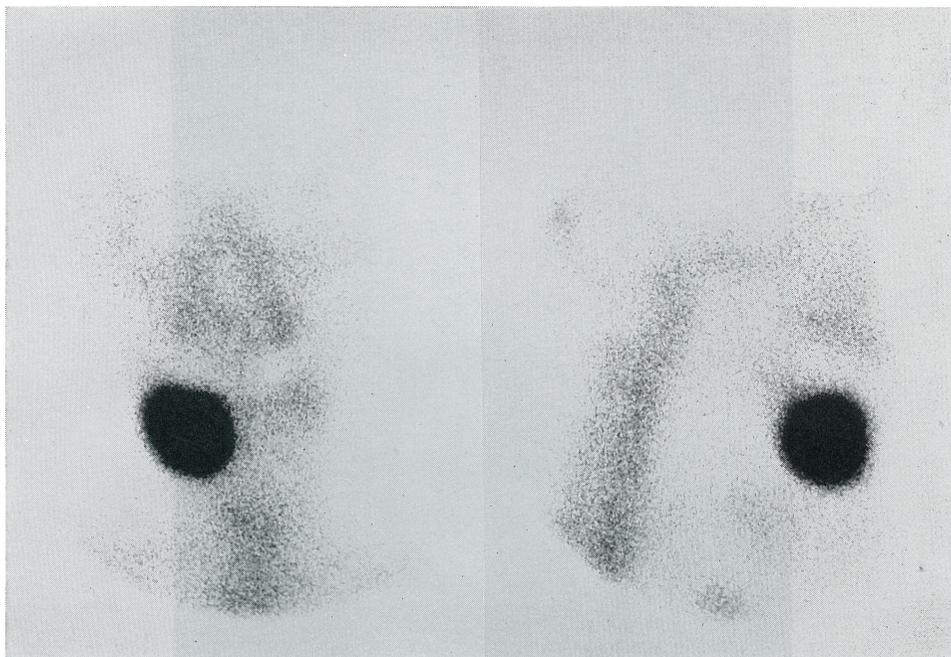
Bone scintigram (Anteroposterior and right lateral view). Diffuse increase in accumulation was seen over the whole mandible. The uptake was especially high on the right side.
